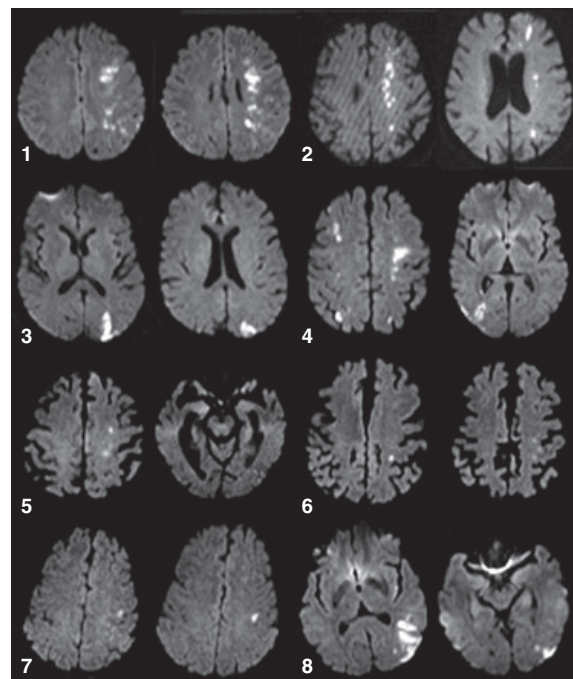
Cerebral diffusion-weighted MRI of the border-zone infarctions (BZI) associated with aphasia. Left BZI observed in patient 1 (MCA/ACA and internal); patient 2 (MCA/ACA, MCA/PCA and internal); patient 3 (MCA/PCA); patient 4 (bilateral MCA/ACA and right MCA/PCA); patient 5 (MCA/ACA and MCA/PCA); patient 6 (MCA/ACA); patient 7 (MCA/ACA) and patient 8 (MCA/PCA BZ infarction). MCA, middle cerebral artery; ACA, anterior cerebral artery; PCA, posterior cerebral artery.
